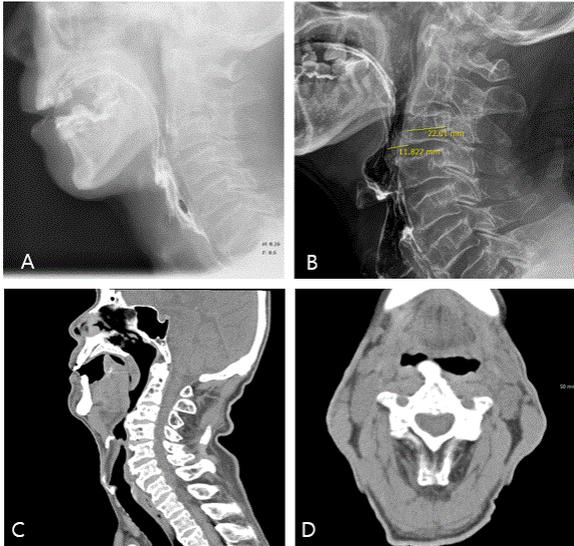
Pooling of barium contrast material in vallecular due to profound mass effect originating from anterior C3-C4 cervical osteophyte in VFSS (A). Large anterior cervical osteophyte in lateral cervical x-ray (B), sagittal view (C) and axial view (D) of CT scan
